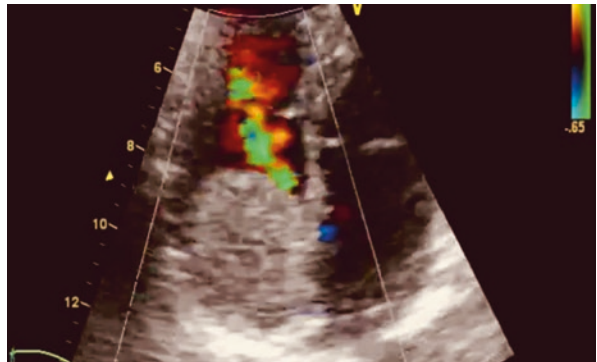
Significant Doppler flow gradient due to large well-circumscribed echo-dense mass that obstructing the tricuspid valve annulus (Velocity: 2 m/s)
